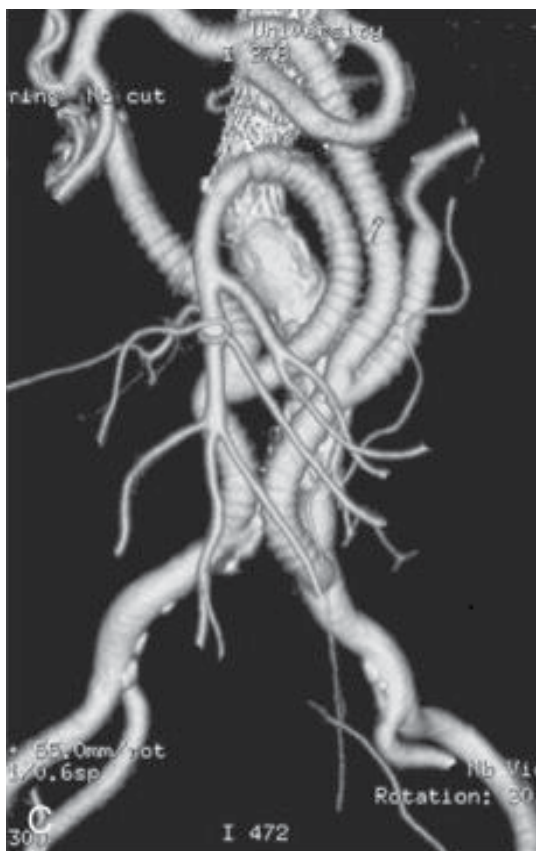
Postoperative CTA of a hybrid reconstruction of a type IV thoracoabdominal aneurysm
